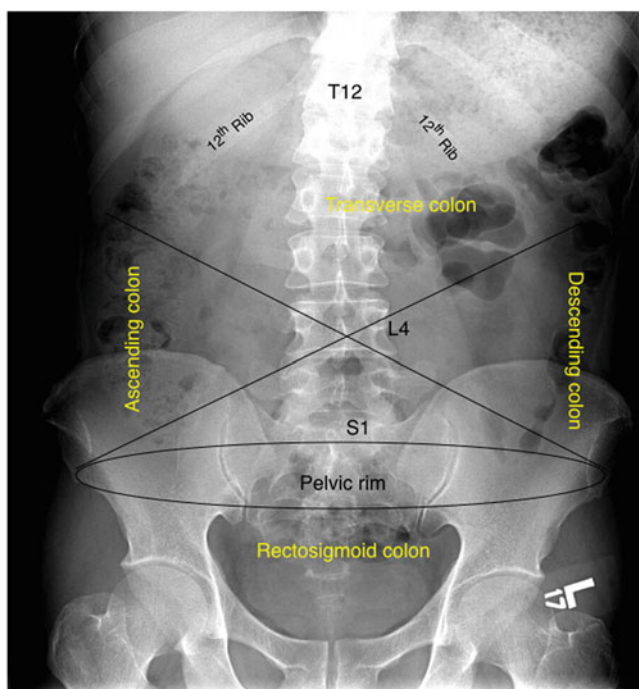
Diagnostic landmarks on abdominal radiograph in patient with constipation
